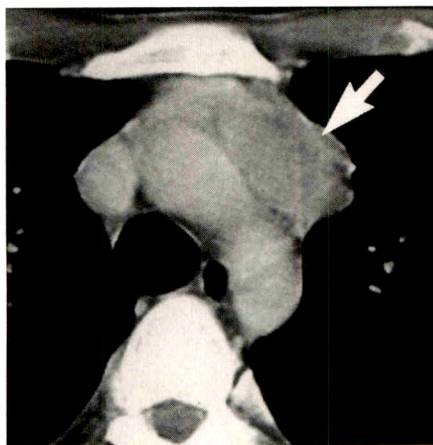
29-year-old man with recent onset of myasthenia gravis and thymoma that was seen to be invasive at surgery. CT shows oval mass (arrow) of left lobe of thymus consistent with diagnosis of thymoma.
